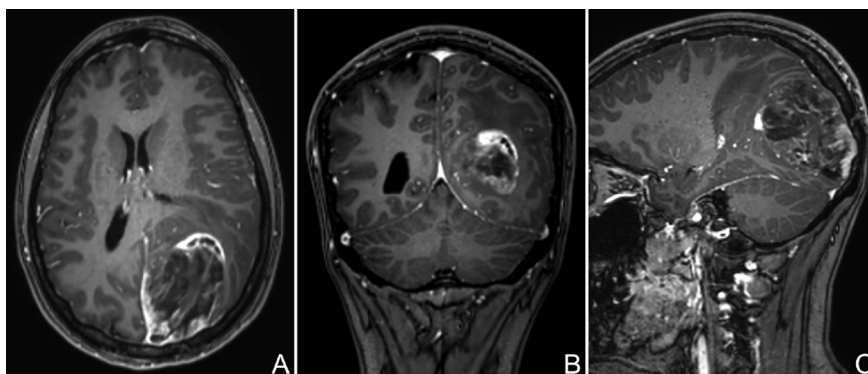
Axial (a), sagittal (b) and coronal (c) contrast-enhanced T1-weighted MRI demonstrating a heterogeneously enhancing left occipital mass lesion.
